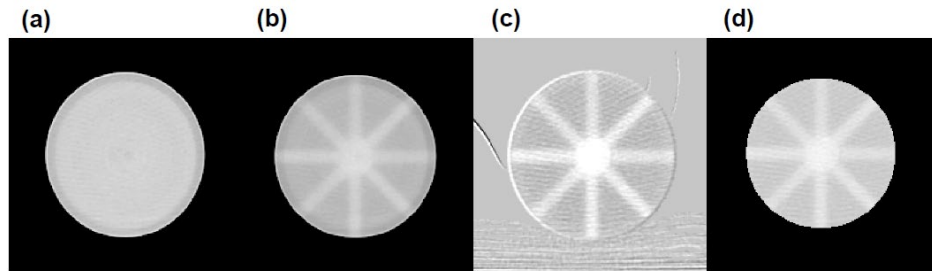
Axial slices of the (a) pre-CBCT image, (b) post-CBCT image, and (c) subtracted CBCT image for the isocenter verification test performed using the 5 mm diameter MLC field. Also shown in (d) is the dosimeter after applying a mask to eliminate the background.
